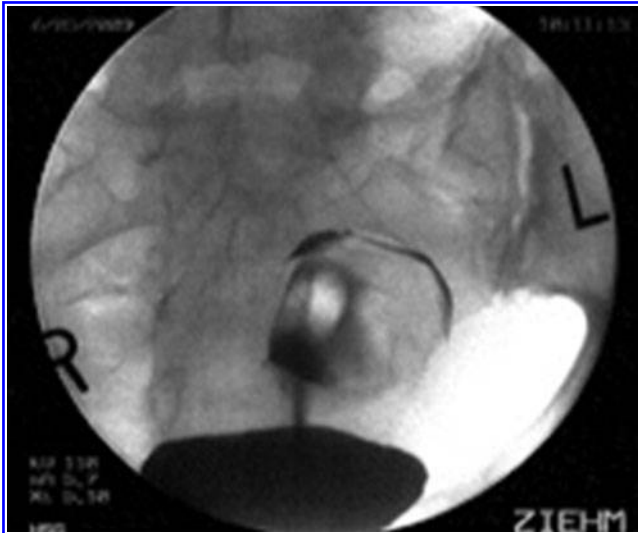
Hysterosalpingogram picture showing the uterine cavity to be occupied and compromised by a large filling defect with a smooth surface, most probably representing a submucous myoma. Taken from ISBN: HB 9781107029743. Edited by Botros R.M.B. Rizk and Elizabeth Puscheck. Ultrasonography in Gynecology. Figure 14 in the book chapter "Transvaginal ultrasound scan findings of uterine fibroid effect on treatment plan." By Dr. Mostafa Abuzeid and Salem Joseph. Copyright © 2012 Cambridge University Press. Reprinted with the permission of Cambridge University Press.
